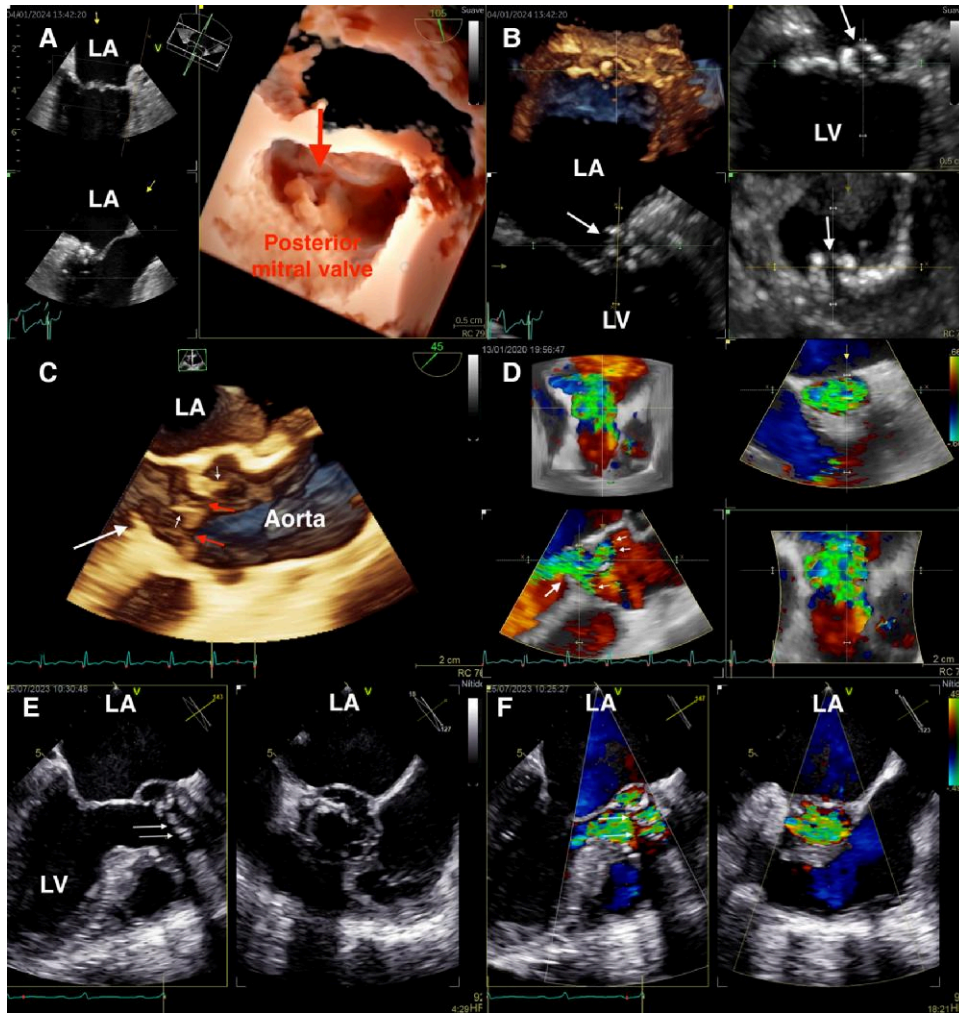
Perforations. (A) TOE at mid-oesophageal level acquired at 105°, volume rendering with transillumination. Oblique atrial view of the mitral valve. A perforated aneurysm is observed in the posterior mitral leaflet (Video 6). (B) MPR of the same case, showing the perforated aneurysm located in P2 in multiple views. (C) TOE at mid-oesophageal level acquired at 45°, volume rendering. Native aortic valve with multiple small vegetations (small white arrows) and two perforations in the non-coronary and right leaflets (red arrows). Note the presence of a subaortic membrane (large white arrow). (D) MPR with colour Doppler of the previous study, showing multiple perforations (small white arrows) causing severe aortic insufficiency. Regurgitant jet with restricted trajectory due to subaortic membrane (large white arrow). (E) TOE at mid-oesophageal level acquired at 143°, simultaneous biplanar image. Biological aortic prosthesis with evidence of multiple fenestrations in its leaflets (white arrows). (F) Biplanar image with colour Doppler of the previous image, highlighting multiple non-eccentric regurgitant jets (white arrows) almost completely occupying the left ventricular out-flow tract (Video 7). LA, left atrium; LV, left ventricle.
